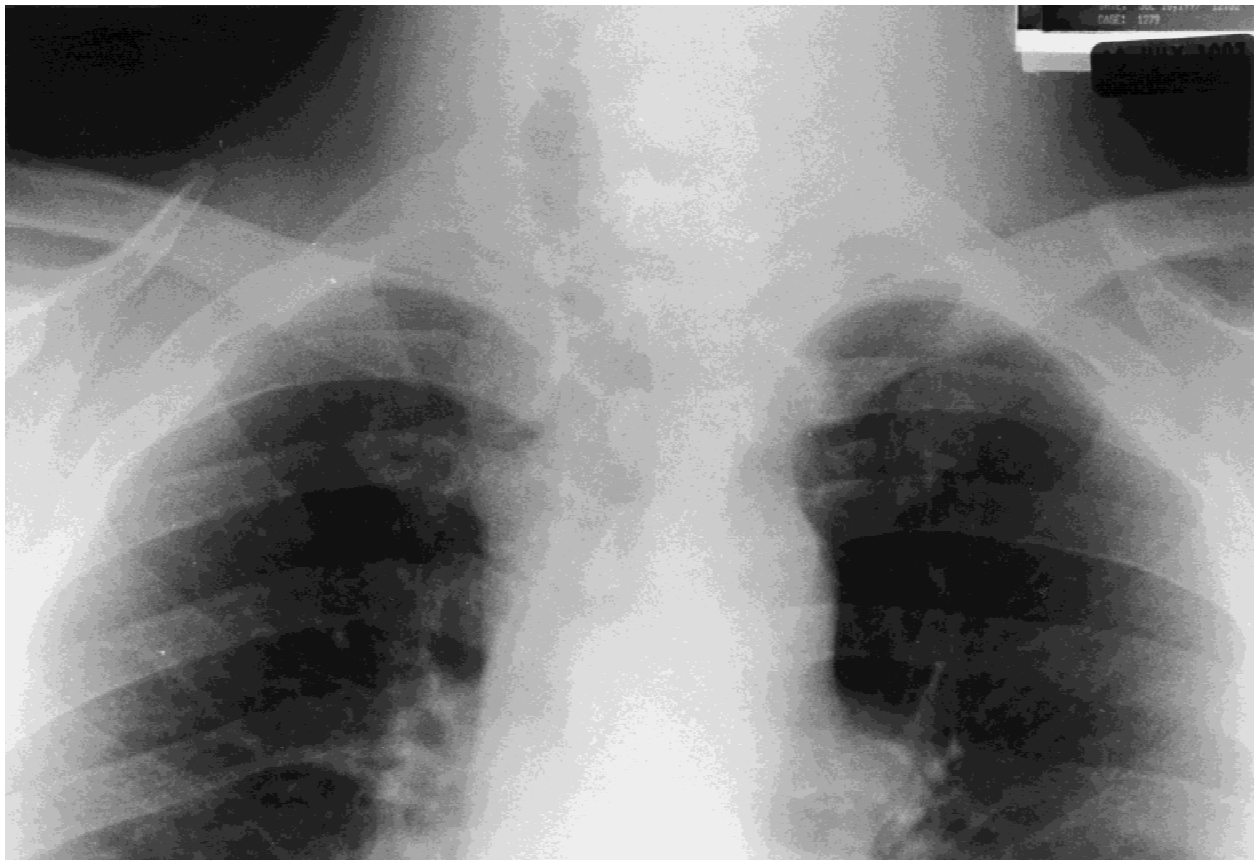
A 50-year-old morbidly obese man was admitted for a rapidly enlarging left neck mass with compressive symptoms of dysphagia and shortness of breath. Plain X-ray film revealed a deviated trachea toward the right side.
